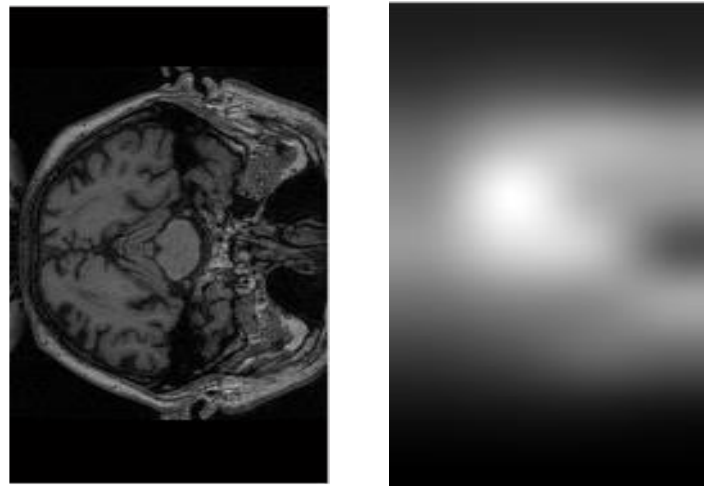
Original abnormal MRI Image Saliency of original image
